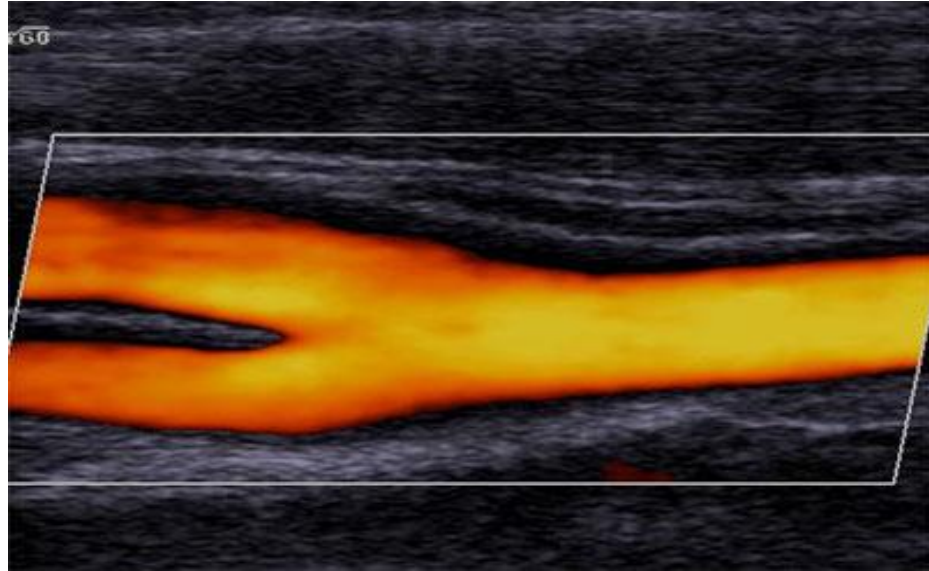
Power Doppler showing Common carotid Artery and Its branching site.
